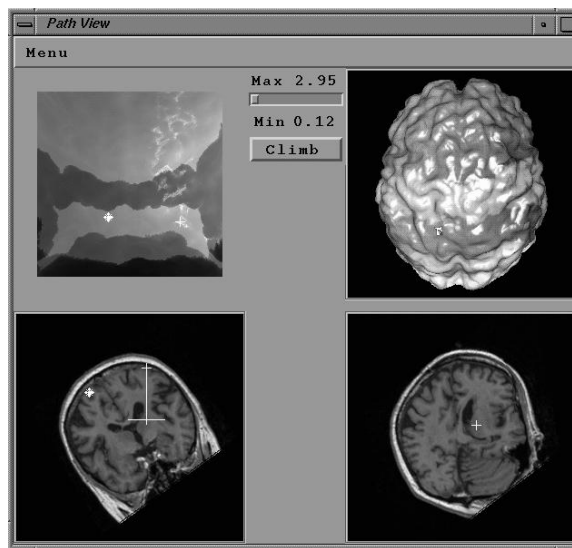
The layout of the path planning software interface. The upper right window shows a 3D rendering of the outer boundary of the brain with cost superimposed in a color scale. The planar domain in which this surface is parameterized is displayed in the upper left window. The lower left window displays a cross-section through the MRI volume containing a particular trajectory. The lower right window displays cross-sectional images oriented perpendicularly to the surgical path. The surgeon can visualize the cost associated with each entry point on the outer boundary of the brain, can click on a particular entry point on the upper left window (which is also displayed on the 3D rendered surface on the upper right window) and visualize any cross-section containing the corresponding path in lower left window, as well as visualize the orthogonal cross-sections of that path in the lower right window.
